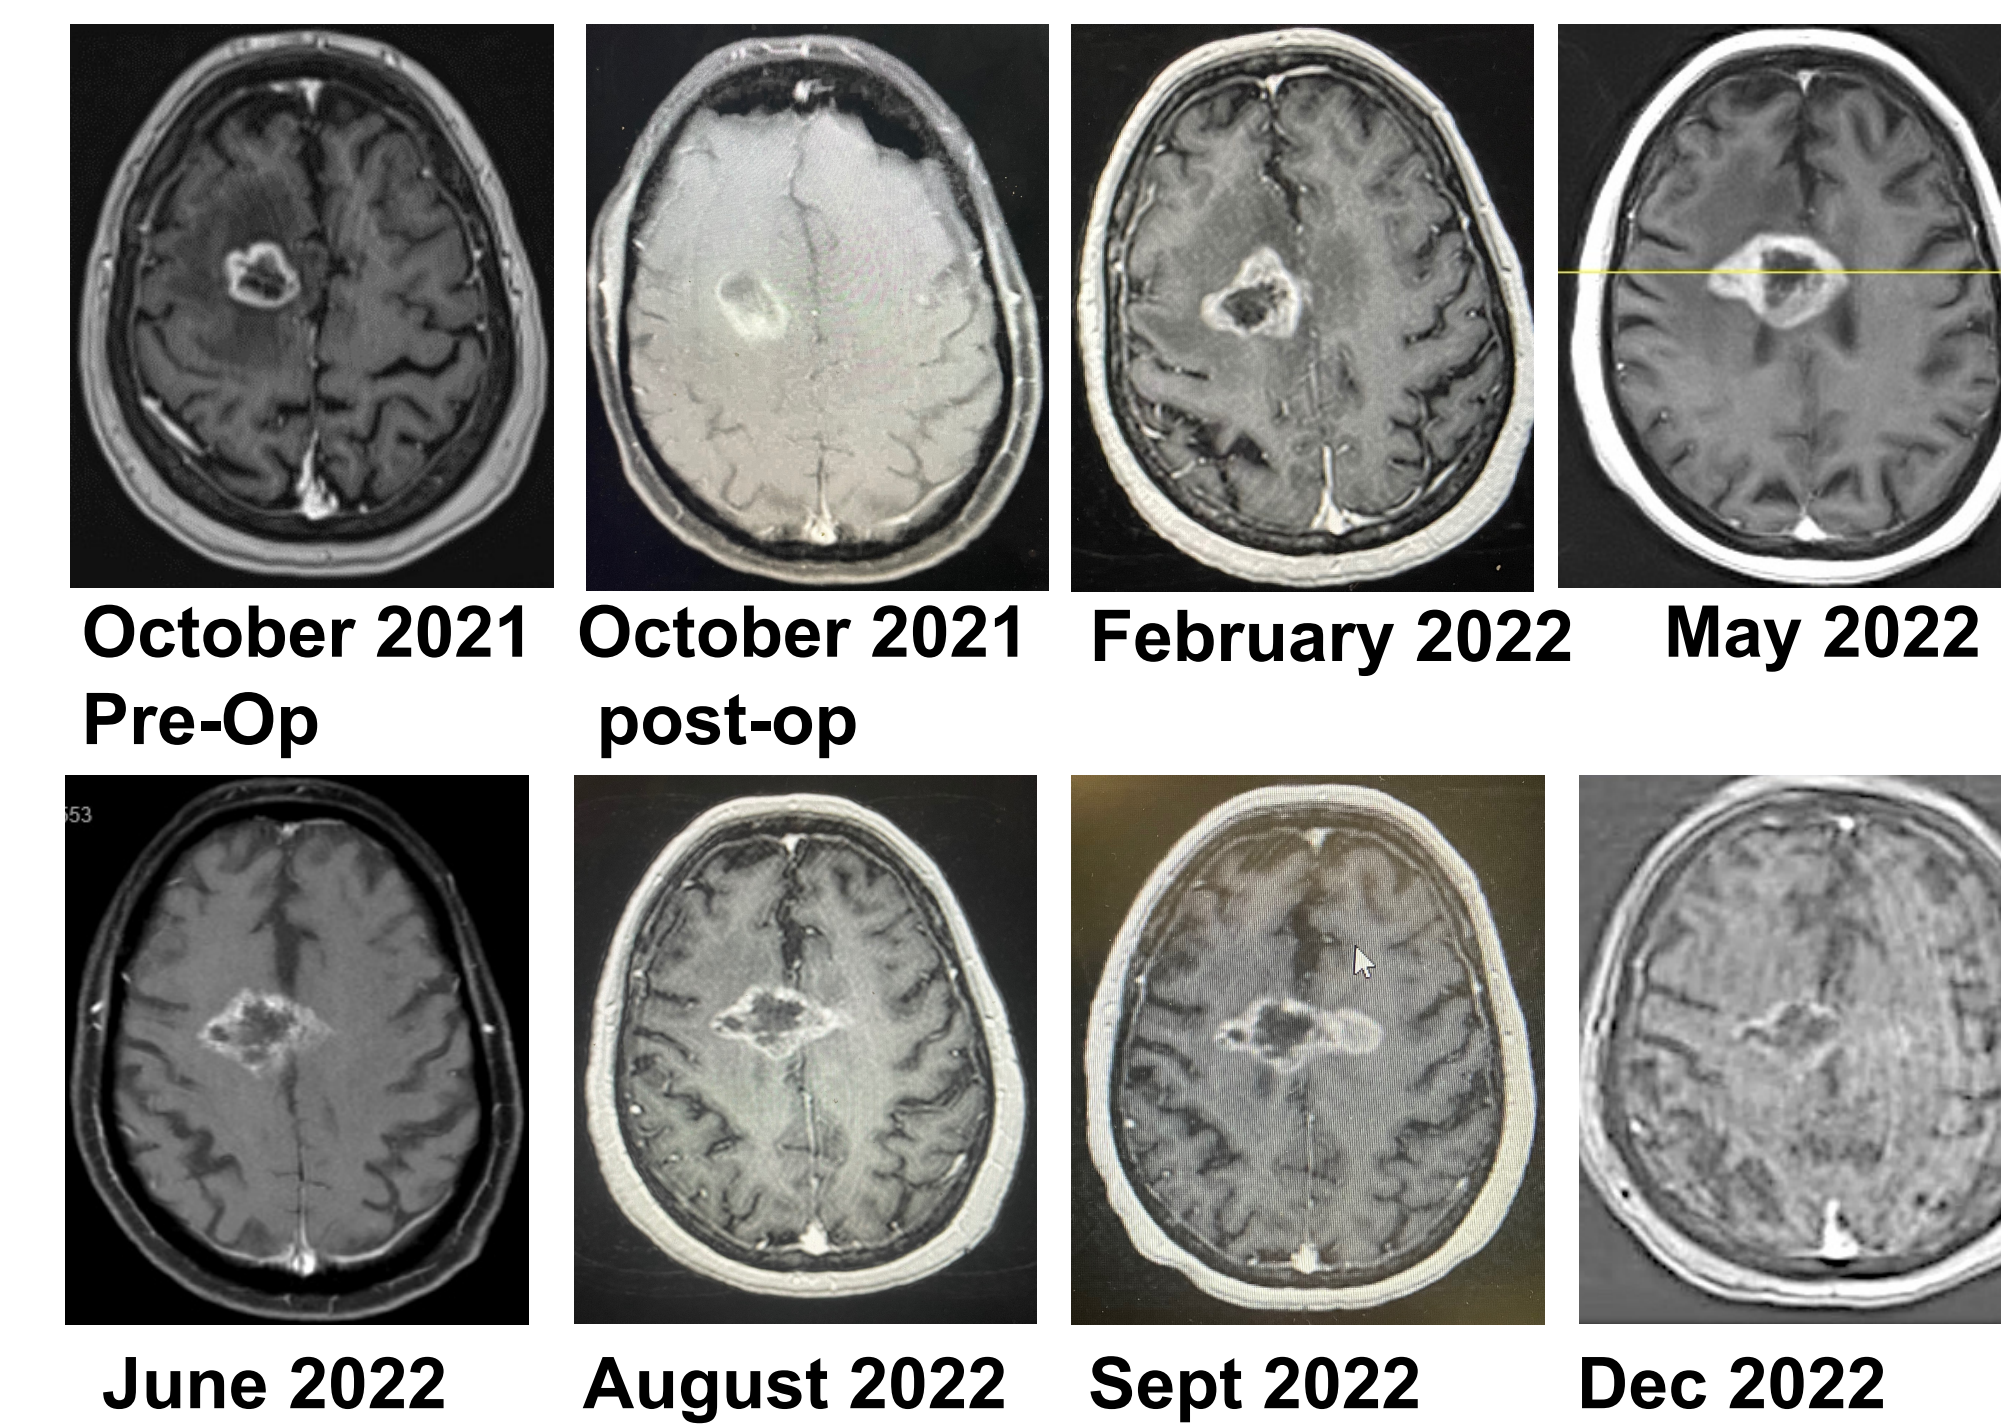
Pre and post operative MRI images of the patient GBM-MDAC-001 (dose cohort 1) reveal significant reduction in the tumor mass.
